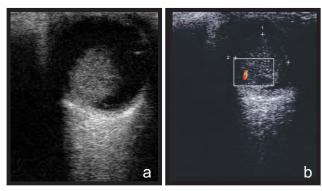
A 2 years old girl presented with complain of Leucocoria in right eye. USG examination revealed large well-defined homogenous hypoechoic lesion in vitreous cavity without presence of calcification which is forming acute angle with retina (a), Color doppler study of lesion showed presence of vascularity within (b)
